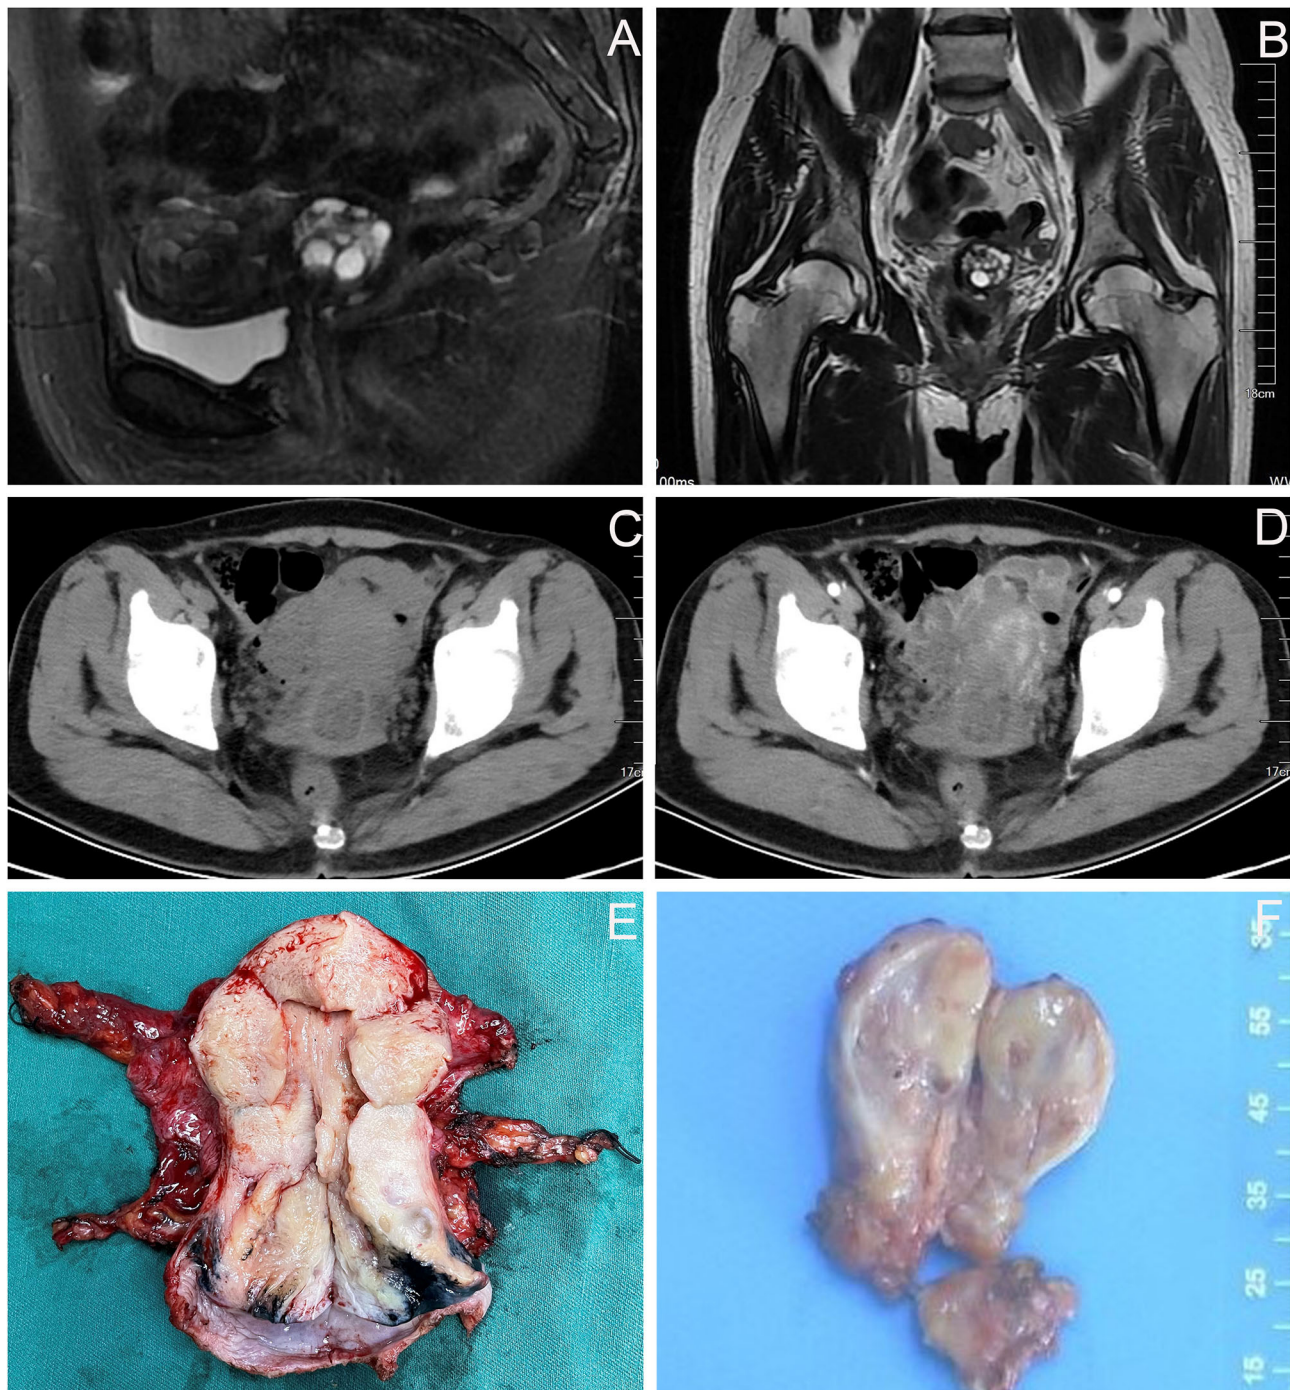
Imaging findings of the patient before and during the second operation. (A,B) Pelvic MRI: the cervix was plump, with an uneven equal T1 and slightly higher T2 signal shadow, which was mainly located in the posterior lip of the cervix, about 3.5×2.7 cm, in which there were many small circular long T1 and long T2 signal shadows. (C,D) Abdominal CT: the cervical was slightly plump, and multiple low-density small nodules could be seen in it (overall range of about 2.8×2.5 cm), and the enhancement was not obvious. (E) The cervix was slightly plump. (F) The appearance of the left ovary was normal, a tumor of approximately 1.5×1.3 cm was seen inside, the cut surface was yellowish white, multiple cystic cavities were seen around.
